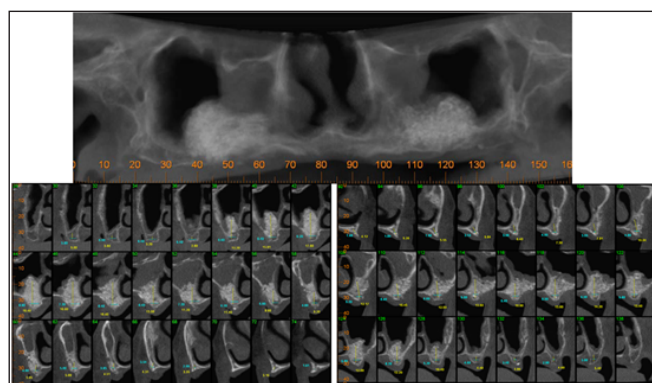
Cone beam computerized tomography. Following the bilateral sinus lift augmentation procedure.
